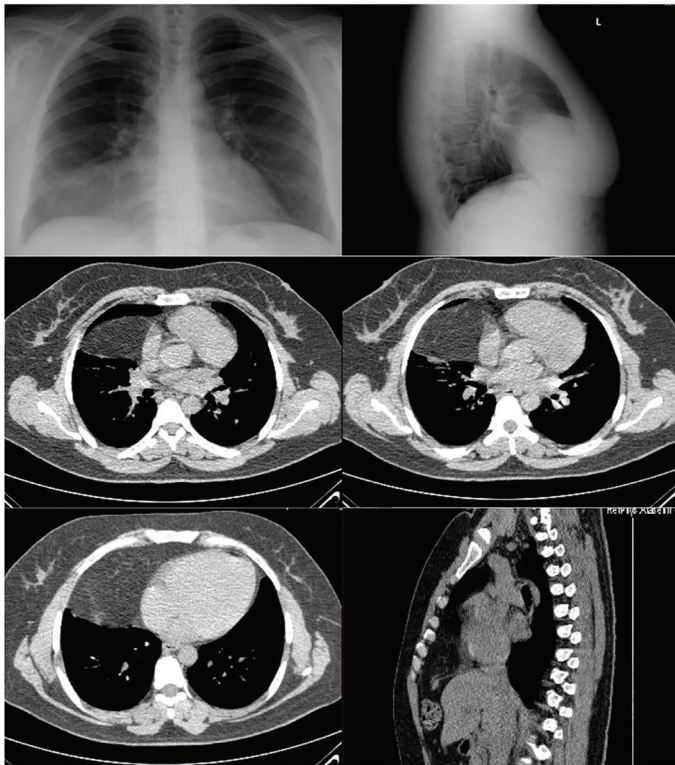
Preoperative posteroanterior, lateral chest X-ray and thorax CT images of the patient
